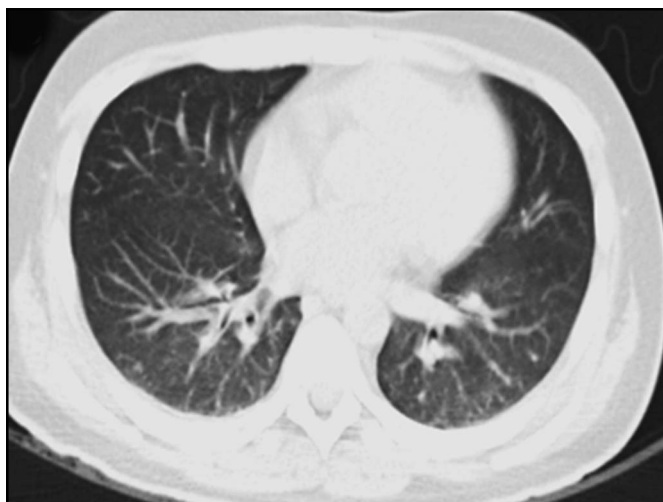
Thoracic computed tomography after 32 days of steroid use.
